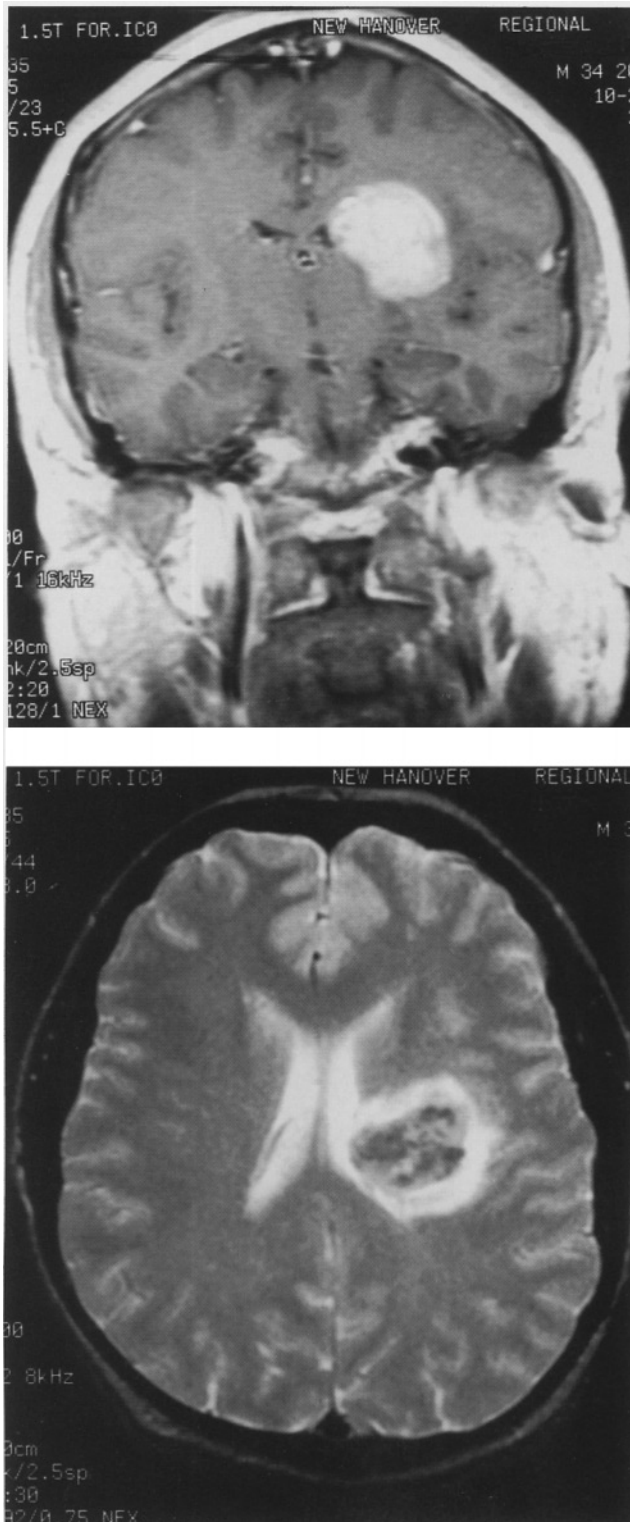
MRI of the brain demonstrating the left cerebral mass.
